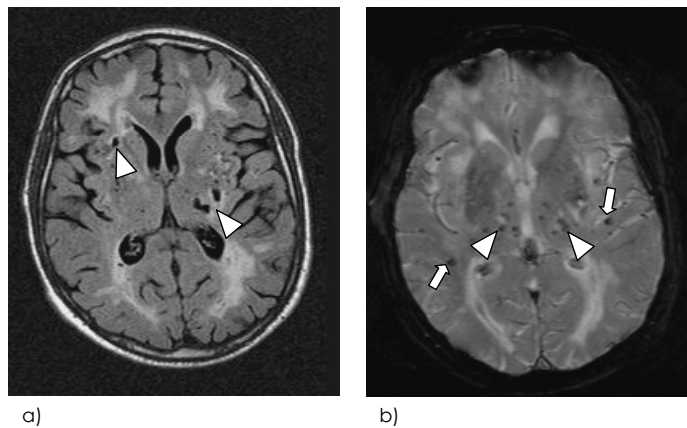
MR images at the level of the basal ganglia in a 55 year old patient with CADASIL. FLAIR image (a) shows periventricular and deep white matter hyperintensities and lacunes in the thalamus and basal ganglia (arrows). T2*-weighted gradient echo planar image (b) shows numerous circumscribed hypodense lesions from previous microbleeds, located in the thalamus (arrowhead) as well as deep and subcortical white matter (white arrow).
